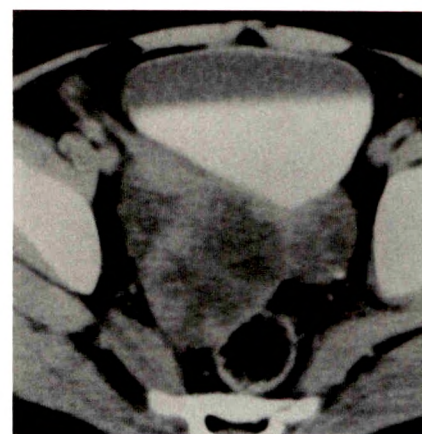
Case 3: Contrast-enhanced CT shows a complex mass anterior to the rectum. Exploration showed 720° torsion of the right ovary with hemorrhage and necrosis.
